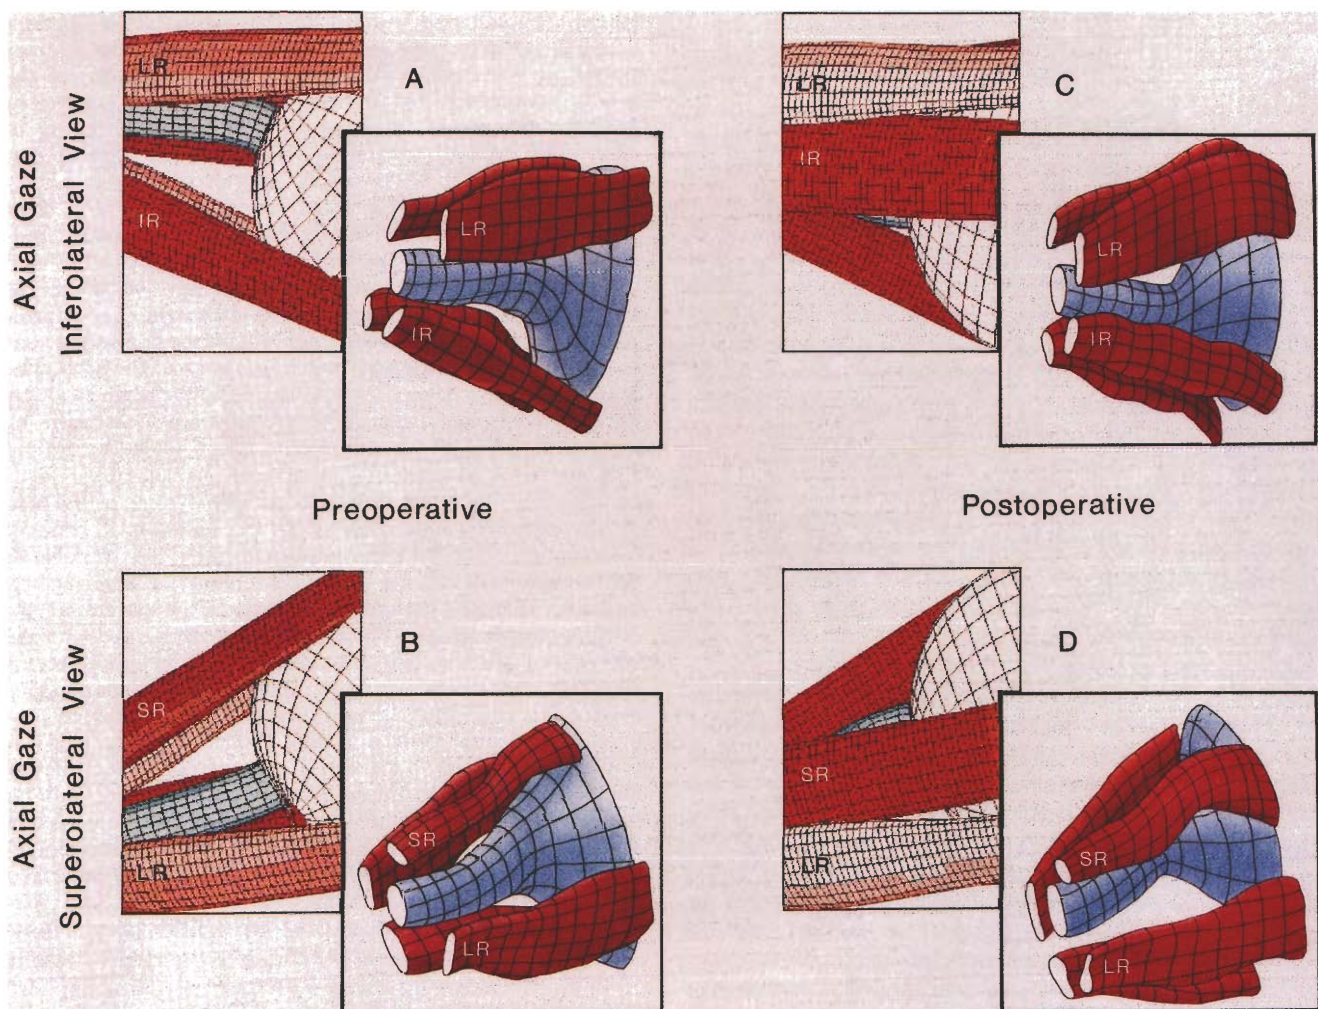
Case 4. Three-dimensional magnetic resonance imaging orbital reconstructions. Format as in Figure 5. A, inferolateral view of the preoperative right eye. B, superolateral view of the preoperative right eye. C, inferolateral view of the postoperative right eye. D, superolateral view of the postoperative right eye.
